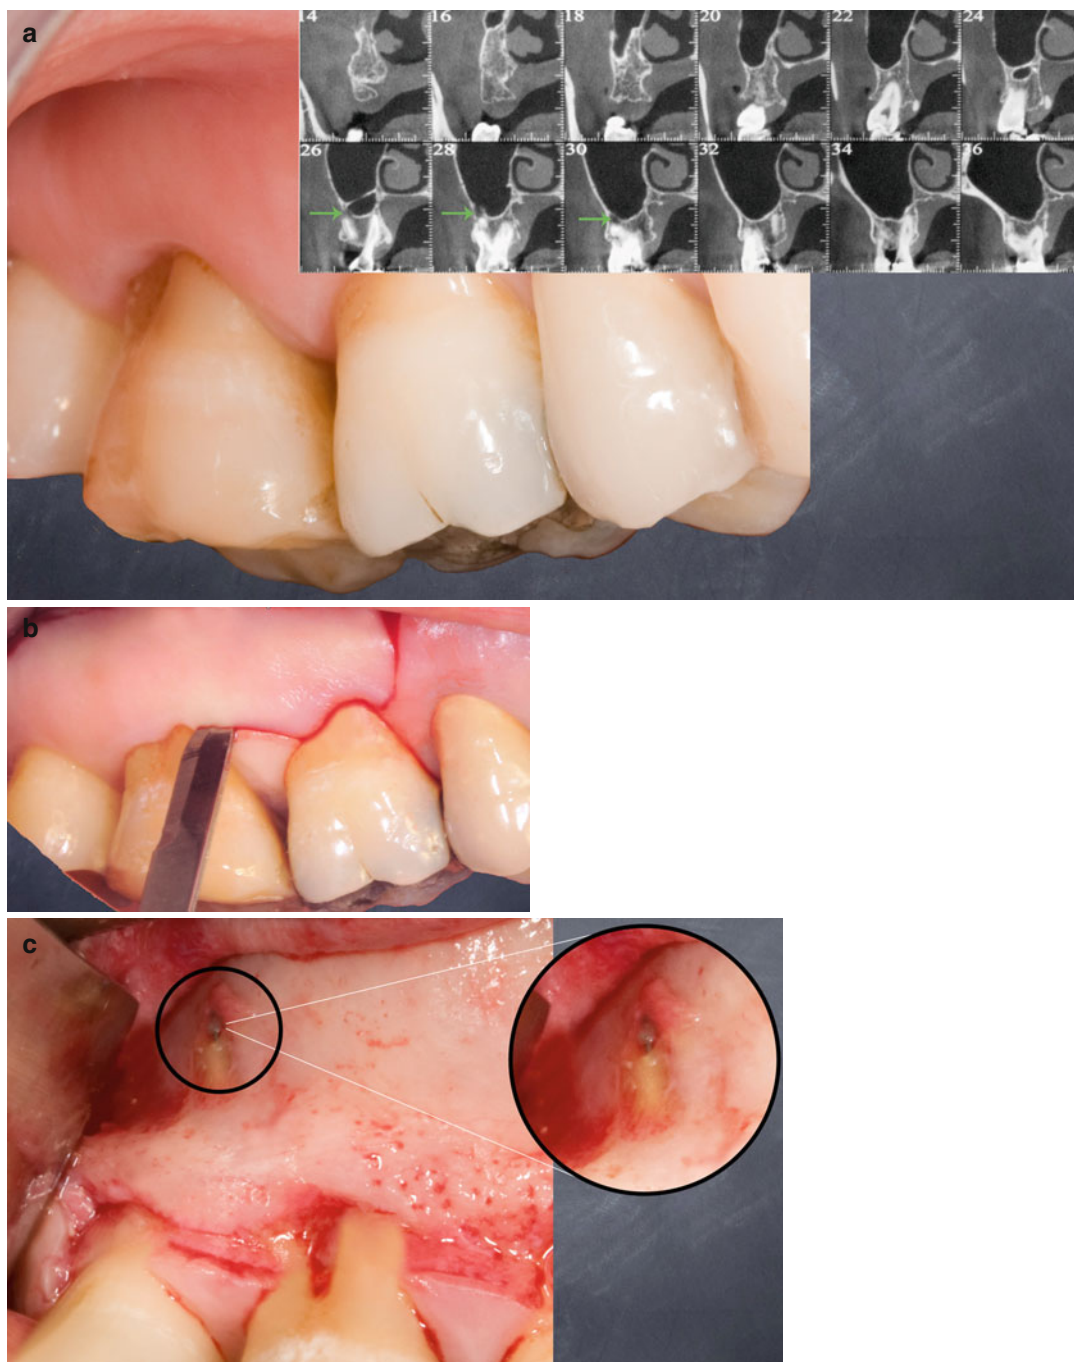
A step by step case of endodontic surgery of a first upper maxillary tooth with close periapical lesion proximity to the maxillary sinus. Two apical roots were involved. Perforation to the sinus. An endoscope was used to explore both the root and the sinus cavity. An absorbable hemostatic gelatine sponge was placed into the bone
